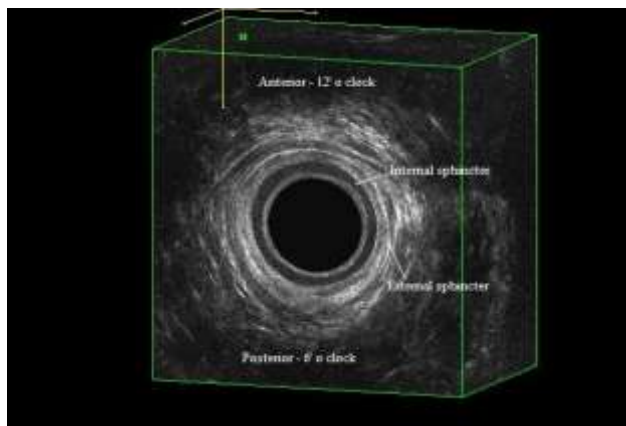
3D Endoanal ultrasound scan image of a normal anal canal.
